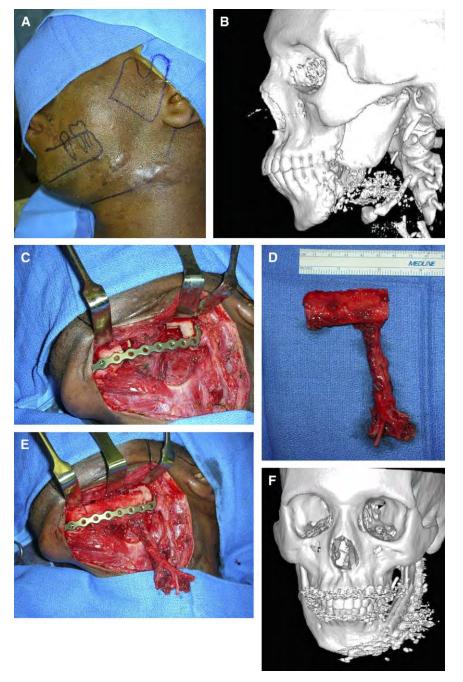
(*A*) Skin markings with planned incisions. (*B*) A three-dimensional CT scan shows a segmental mandibular defect of the mandible. (*C*) Mandibular defect with reconstruction bar in place. (*D*) Prepared fibula bone flap before inset. (*E*) Inset of fibula bone segment into the mandibular defect before securing the graft and anastomosis. (*F*) Postoperative three-dimensional CT scan. Note the inset fibula and the adequacy of the width of the fibula for osseous implant placement.
